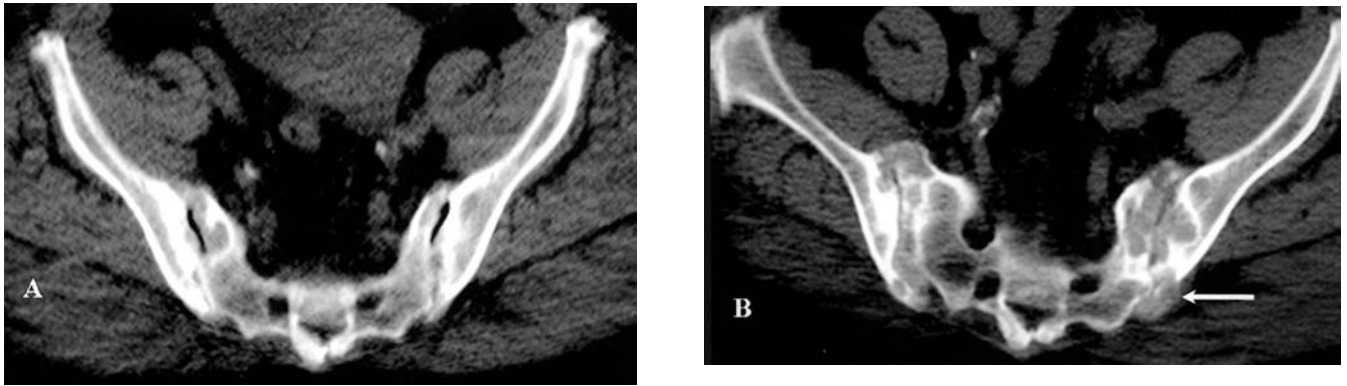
A. CT at the S3 level showing bilateral sclerosis of the sacroiliac (SI) joints with small erosions in both articular surfaces. Study performed 1 year prior to the diagnosis of tophaceous gout. B. CT at the S3 level at the time of diagnosis shows marked progression of the described changes. Sacroiliitis stage 3 (New York criteria). Bilateral widening of the SI joints and punched-out subchondral cystic lesions of varying sizes within the articular surface. Arrow indicates a tophus protruding into the adjacent soft tissues.
